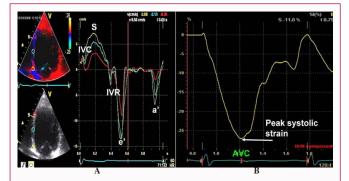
Principle of tissue Doppler image.
